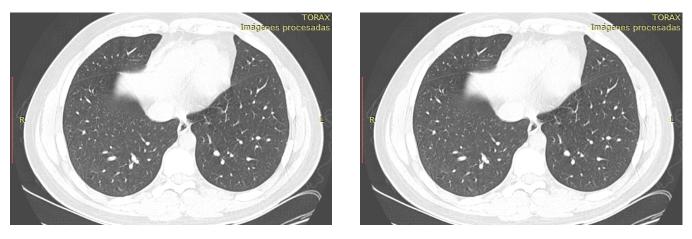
Control chest computed tomography: normal.
